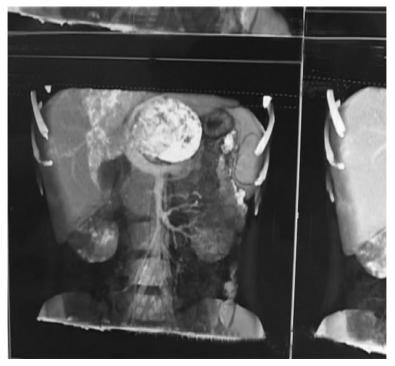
CT showing the tumor is embraced by the PV
